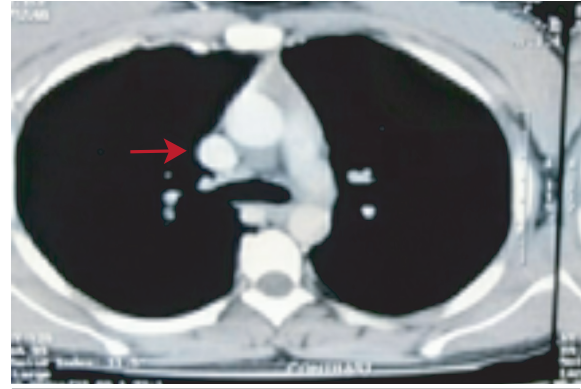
Contrast-enhanced computed tomography thorax showing resolution of thrombus after successful treatment.
